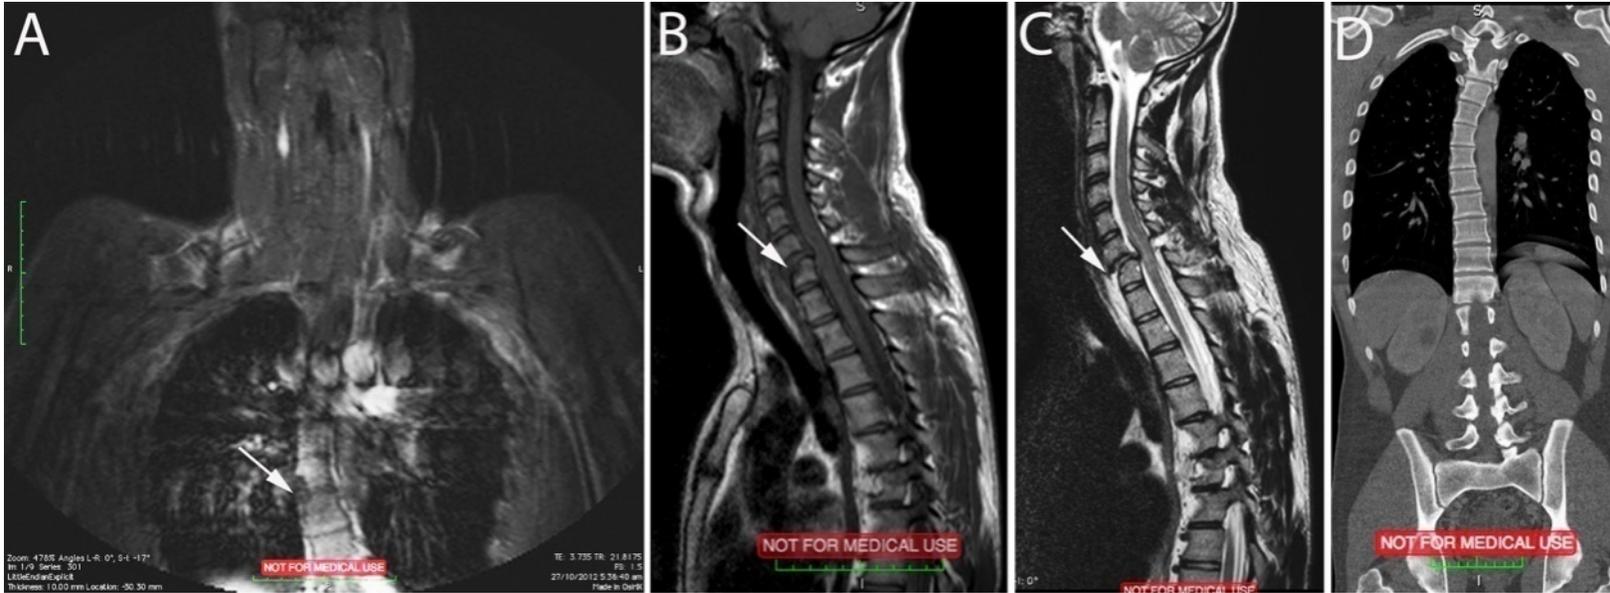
Ben's X-ray images: just after injury (10/2012)
